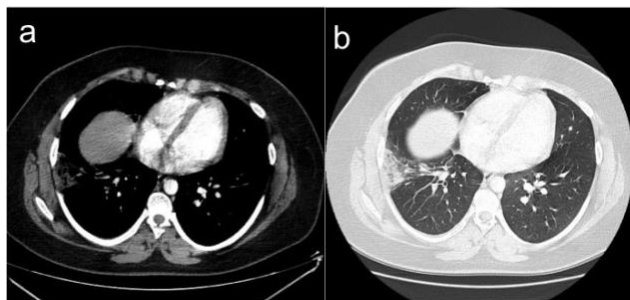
(a and b) Chest CT angiography (axial section) shows a wedge-shaped infarction along right pleural surface.
